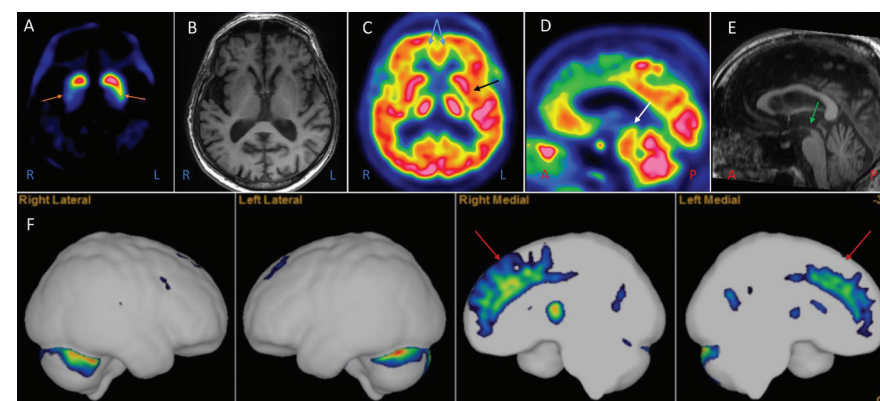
Example of [¹¹C]PE2I PET/MR images in a patient with progressive supranuclear palsy with predominantly left-sided clinical symptoms, axial rigidity and impaired eye gaze. (A) [¹¹C]PE2I images of DAT availability showing reduced uptake in striatum (orange arrows), more pronounced on the right side. (B) MR image (T1-weighted sequence) showing no abnormalities in the striatum. (C) [¹¹C]PE2I image of rCBF showing decreased perfusion bilaterally in medial frontal cortex (blue arrows) and in left putamen (black arrow). (D) [¹¹C]PE2I image of rCBF showing decreased perfusion in midbrain (white arrow). (E) MR image (T1-weighted sequence) showing midbrain atrophy (green arrow). (F) 3D surface projection map showing perfusion z-scores compared to a healthy control database, indicating decreased perfusion bilaterally in medial frontal cortex and anterior cingulate gyrus (red arrows).
